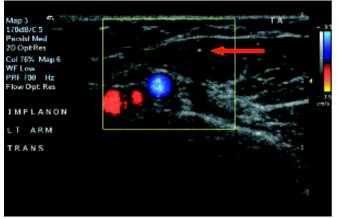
Using color doppler the adjacent vessels can be identified prior to removal.
